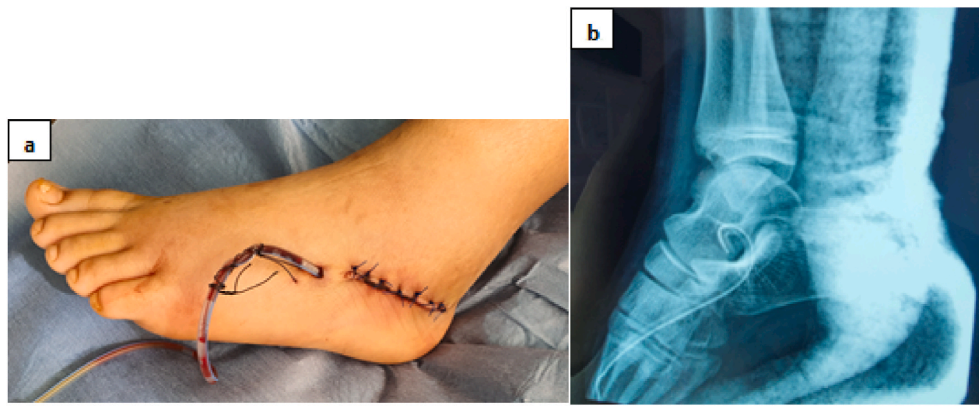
a. post-operative photography, b. post-operative radiography.
